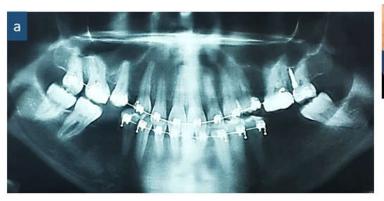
Current state: a: panoramic radiography; b: patient's smile
